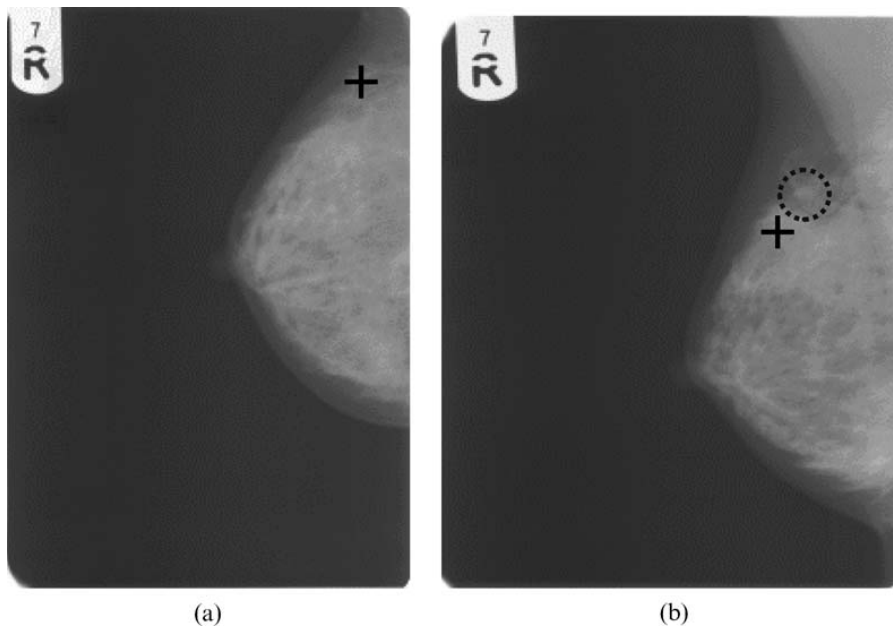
The initial clinical assessment of the extended cranial-caudal mammogram (a) did not reveal any suspicious regions of interest. The medial-lateral oblique mammogram (b) was determined to have a slightly denser region (circled) but did not reveal any pathology with needle biopsy. After registration with the contrast-enhanced MRI projections, the centroid of the region visible in the MRI was projected back onto the mammograms (indicated by +). Biopsy of this region tested positive for malignancy.
